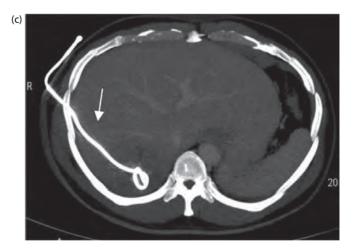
(a) Enhanced CT scan slice through the liver shows an 8 cm abscess in segment VI. (b) Enhanced CT slice following percutaneous CT-guided drain insertion. Note the significant reduction in abscess size. (c) Maximum intensity projection image of the liver similar to Figure 13.4b. The safe intercostal path of the drain is shown (white arrow).
